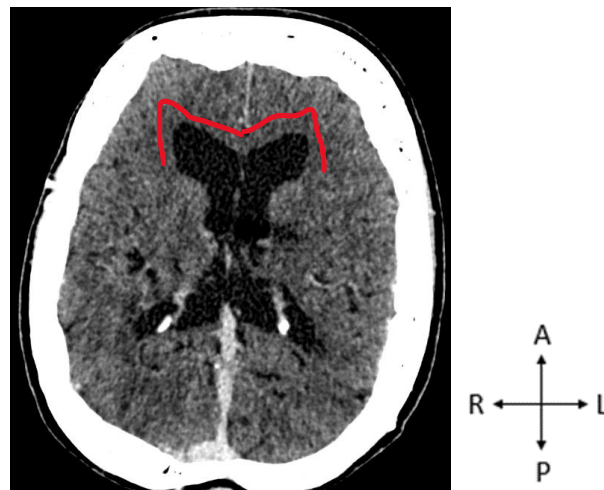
A CT scan of the brain in the axial view indicating the quadrilateral frontal horn shape (red). Image taken from the GSH PACS (20 October 2023). A - Anterior, R - Right, P - Posterior, L - Left.
